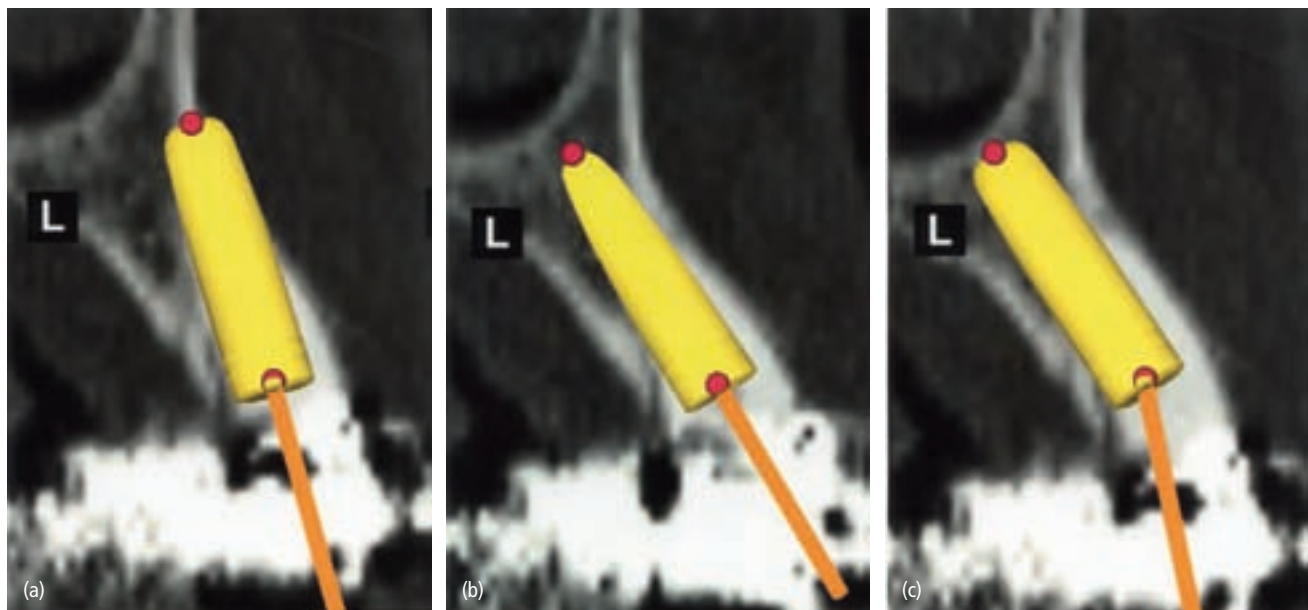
(a) Cross-sectional maxillary radiograph with a virtual anterior implant positioned for ideal restorative position so the long axis emerges through the cingulum. Note the extensive apical fenestration that would occur with this implant position. (b) Ideal anatomic position of an implant in the same site. Note that the long axis of the implant emerges through the facial surface of the tooth. If multiple implants with this degree of facial flaring were to be used to support a restoration then some angulation compensation would be needed to correct for the significant divergence. (c) Implant in ideal anatomic position with prosthetic correction via angled abutment facilitates prosthetic parallelism.
